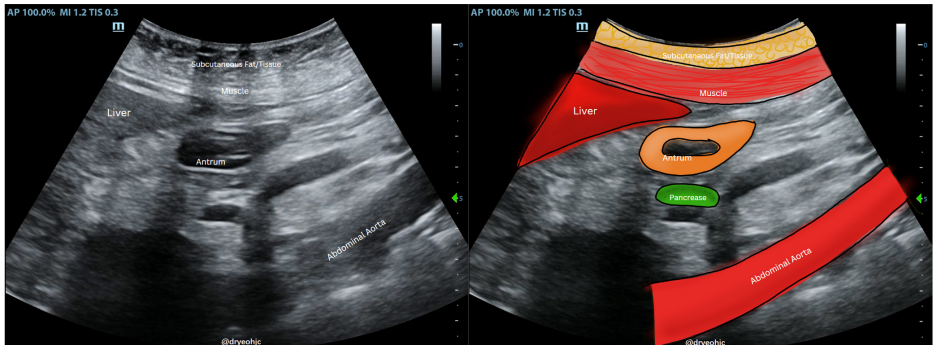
Sonoanatomy to be identified during gastric ultrasound.
